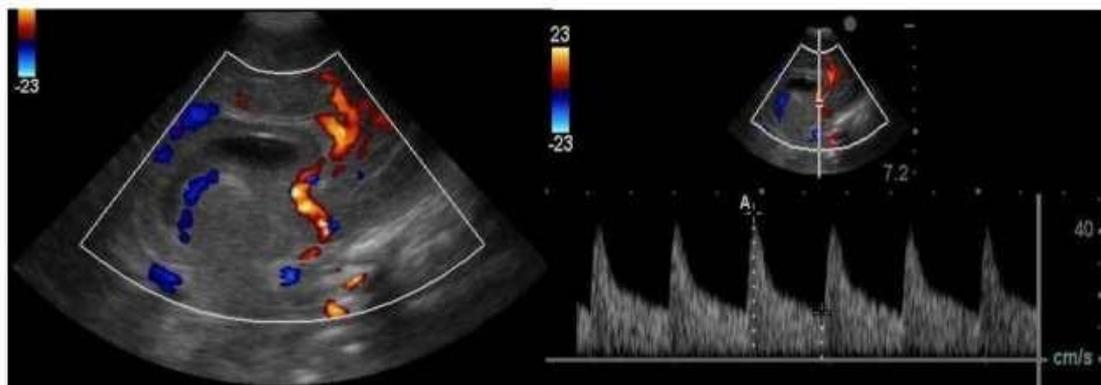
Mid-sagittal image with Doppler of ACA (Day 1).
